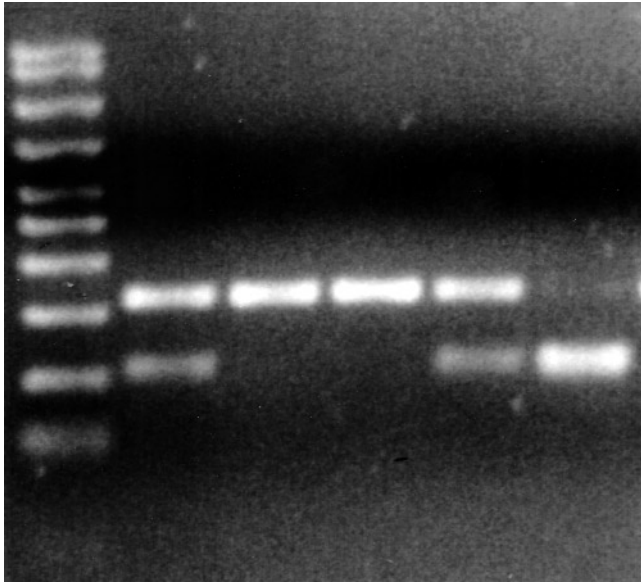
An agarose gel showing bands from patients with the eNOS T-786→C polymorphism. CC homozygotes have the restriction enzyme site and digest to produce 2 fragments, 118 and 105 bp, which overlap to appear as a single band (lane 6). TT homozygotes for polymorphism samples do not digest, and produce a single 223 bp band (lanes 3, 4). CT heterozygotes will digest and produce all bands of 223, 118, and 105 bp (lanes 2, 5). Lane 1: DNA ladder.
